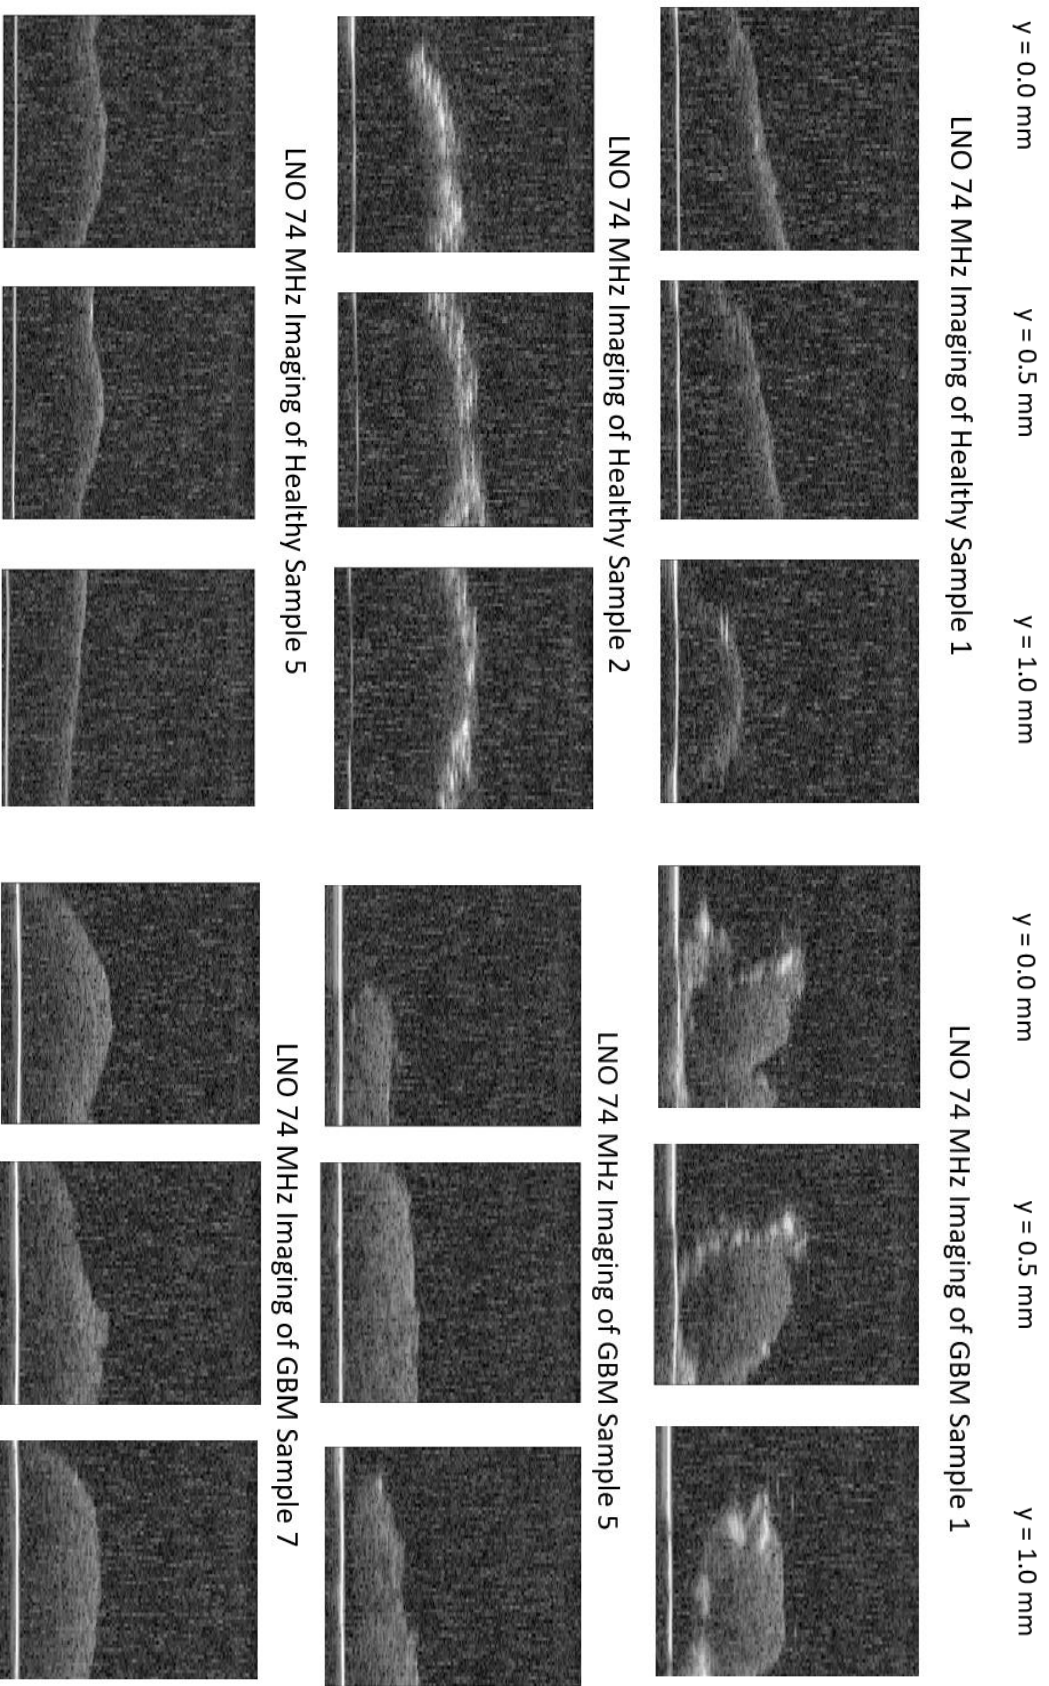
B-mode images of healthy tissue and GBM with LNO microultrasound scanning.
